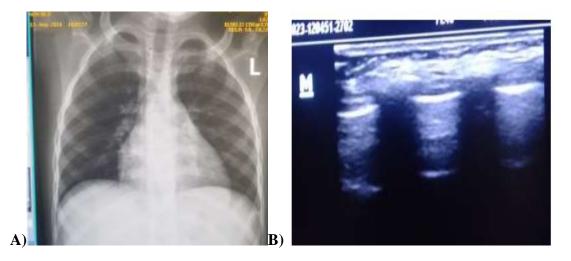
(A case with normal radiological findings): An 8-year-old M who presented with clinical diagnosis of pneumonia. A; shows normal AP chest x-ray findings. B; shows normal lung ultrasound findings.
